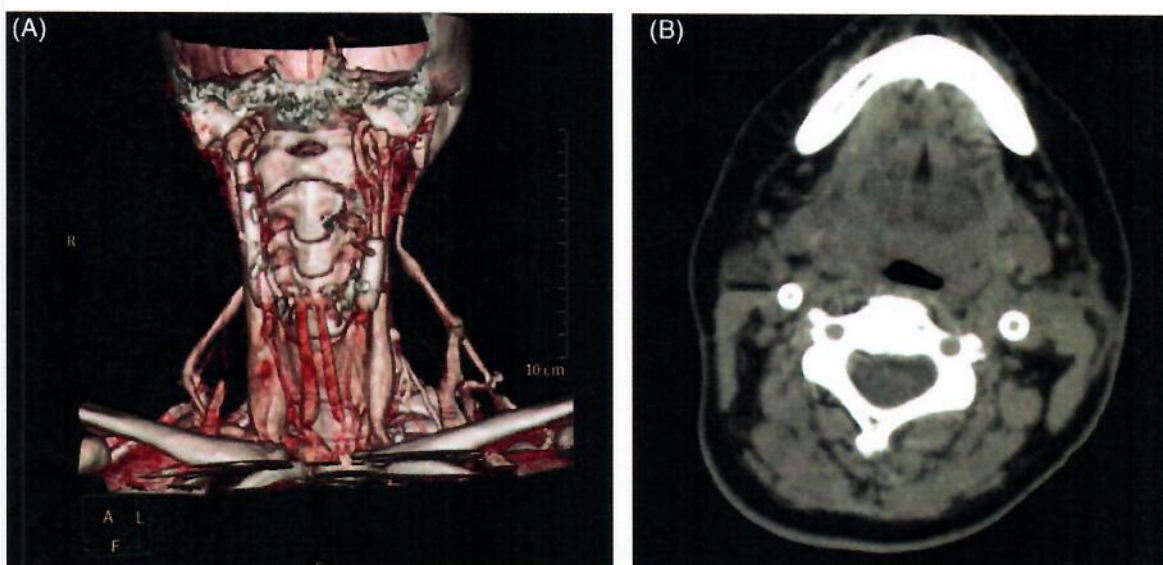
A case of a bilateral carotid body paraganglioma in which the internal carotid artery was stented bilaterally. A, Postoperative 3D reconstruction CT scan showing stents placed in the internal carotid arteries bilaterally. B, Axial CT scan showing the same [Color figure can be viewed at wileyonlinelibrary.com]
